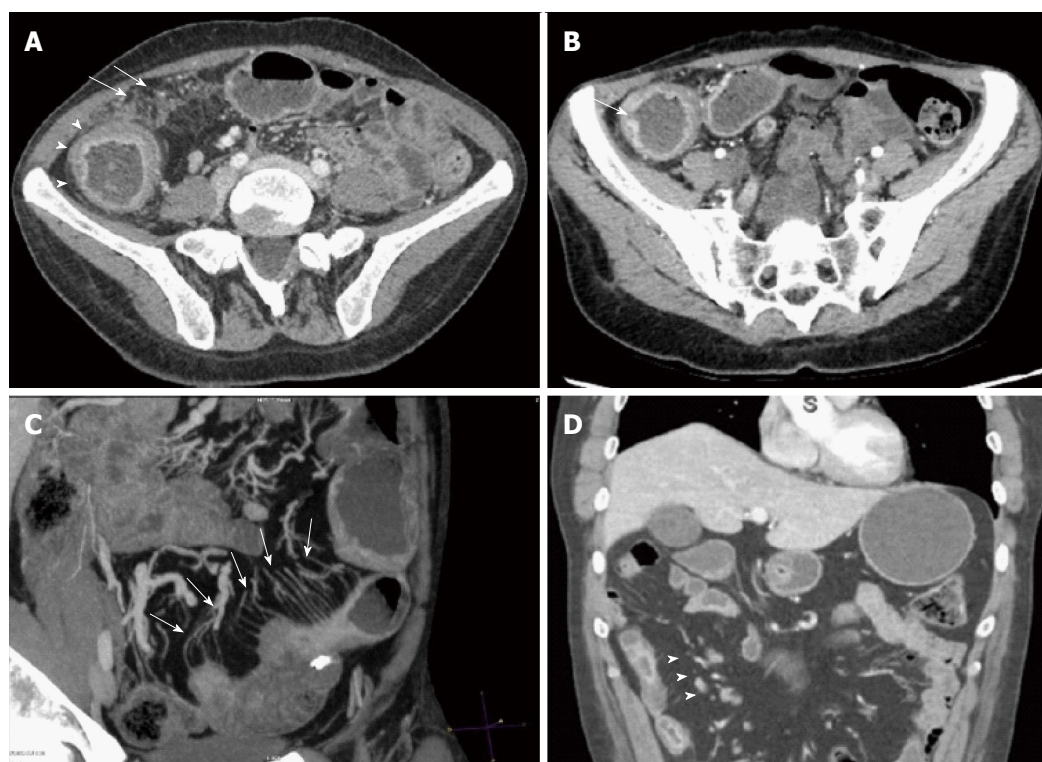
Computed tomography enterography shows signs of inflammatory activity in patients with inflammatory bowel disease. A: Mucosal hyperenhancement, wall thickening with mural stratification (arrowheads), mesenteric fat stranding (arrows); B: Mucosal ulcerations (arrow); C: Hypervascularity of the involved mesentery (comb sign) (arrows); D: Enlarged mesenteric lymph nodes (arrowheads).
